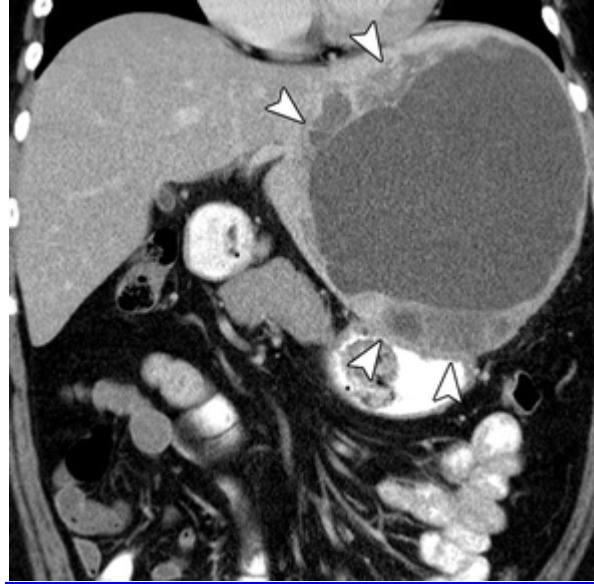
Embryonal sarcoma in 17-year-old boy. Contrast-enhanced CT scan shows cystic lesion within left lobe of liver with heterogeneous irregular enhancement of peripheral portions of mass (arrowheads).
